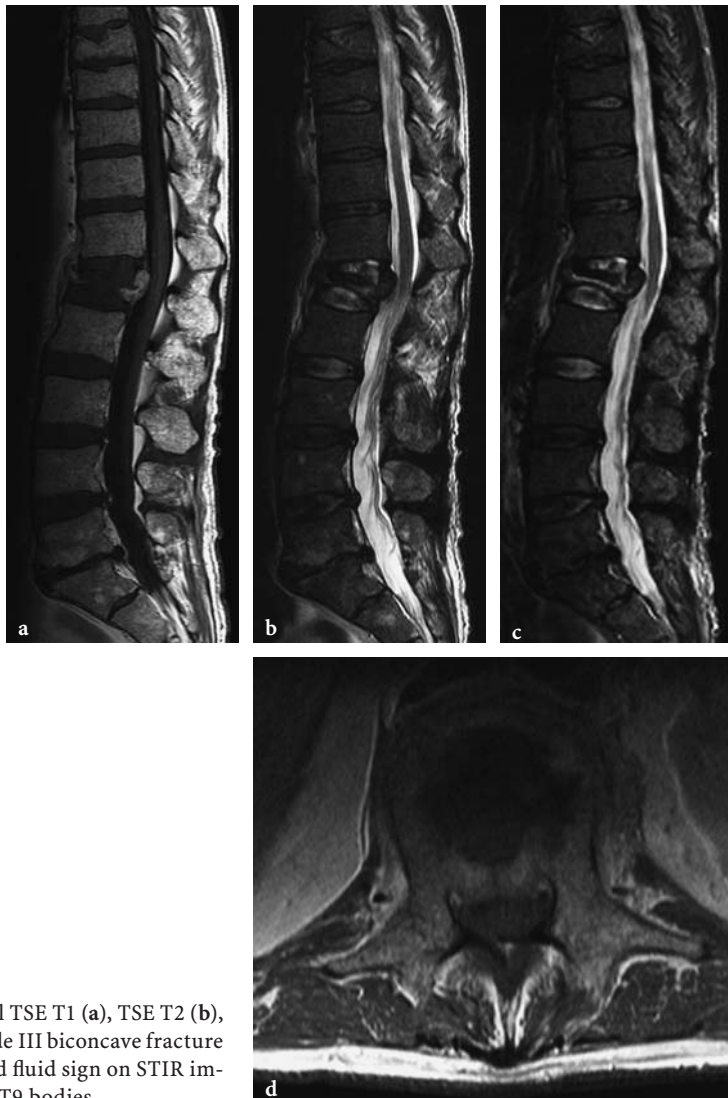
MRI thoracolumbar spine: sagittal TSE T1 (a), TSE T2 (b), STIR (c) and axial TSE T1 images (d). Acute grade III biconcave fracture of L1 with retropulsion of the posterior wall and fluid sign on STIR images. Note also the old fractures of the T8 and T9 bodies
